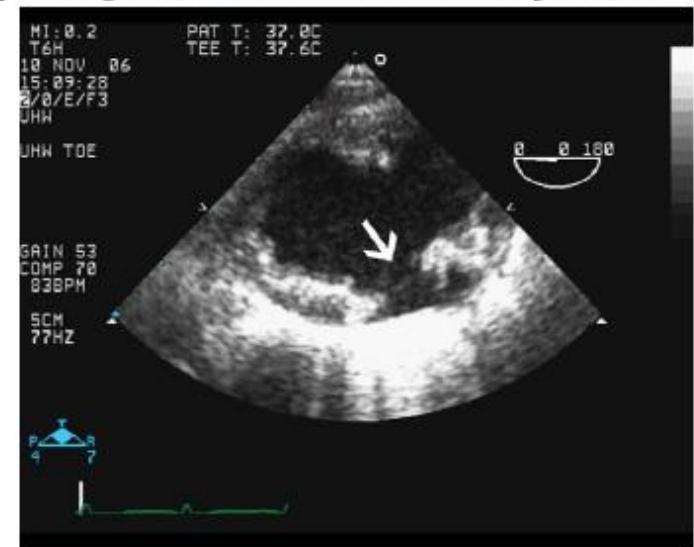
Penetrating atherosclerotic aorta. A transoesophageal echocardiography image of the descending aorta showing severe atheroma with a localized, bulge associated with plaque rupture (white arrow).
